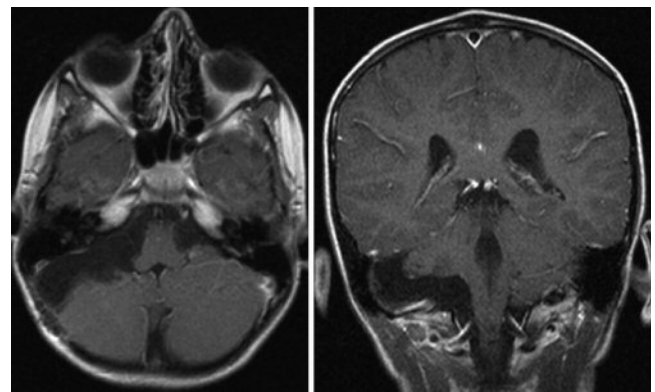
Postoperative axial (*left*) and coronal (*right*) T1-weighted MR images obtained after contrast administration, revealing no apparent residual tumor and decompression of the brainstem.
